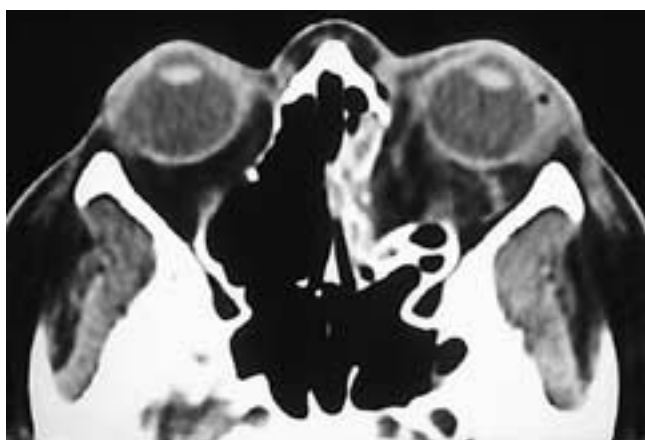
Axial CT scan shows a left medial wall blow-out fracture with a large herniation of orbital fat into the fracture site. This is the type of fracture that can result in chronic enophthalmos.
